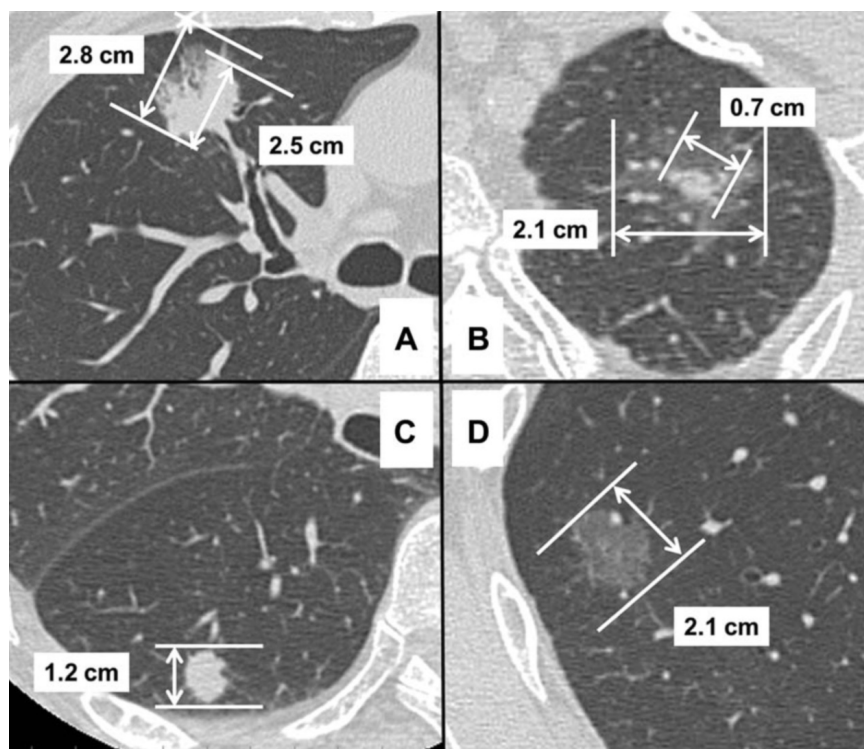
Examples of whole tumor sizes and tumor sizes calculated eliminating the areas of GGO (solid tumor size) on high-resolution computed tomography. A, Whole tumor size: 2.8 cm (T1b) and solid tumor size: 2.5 cm (mT1b). B, Whole and solid tumor sizes: 2.1 cm (T1b) and 0.7 cm (mT1a). C, Whole and solid tumor sizes: 1.2 cm (T1a) and 1.2 cm (mT1a). D, Whole and solid tumor sizes: 2.1 cm (T1b) and 0.0 cm (mTis). GGO, ground glass opacity.
